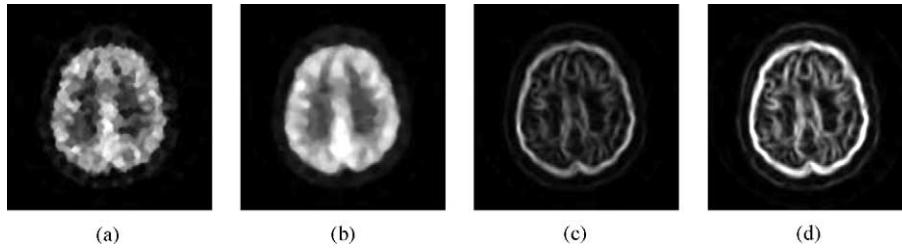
Steps in energy image computation in the case of the FDG-PET brain images. Transaxial image cross-sections from (a) the original image, (b) the median filtered image, (c) the gradient image and (d) the energy image, which is a contrast enhanced version of the gradient image in (c).
